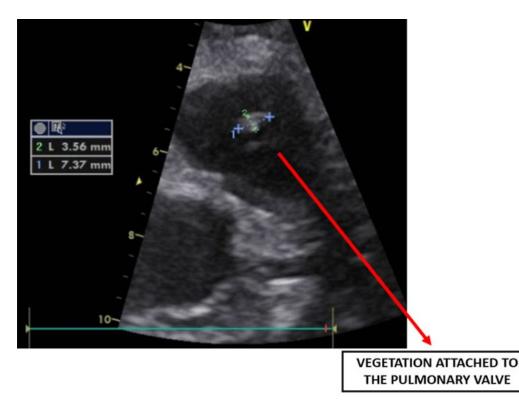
Transthoracic echocardiography basal short axis view showing a vegetation of size 3.56 x 7.37 mm attached to the pulmonary valve (red arrow). The yellow V signals the transducer marker.
